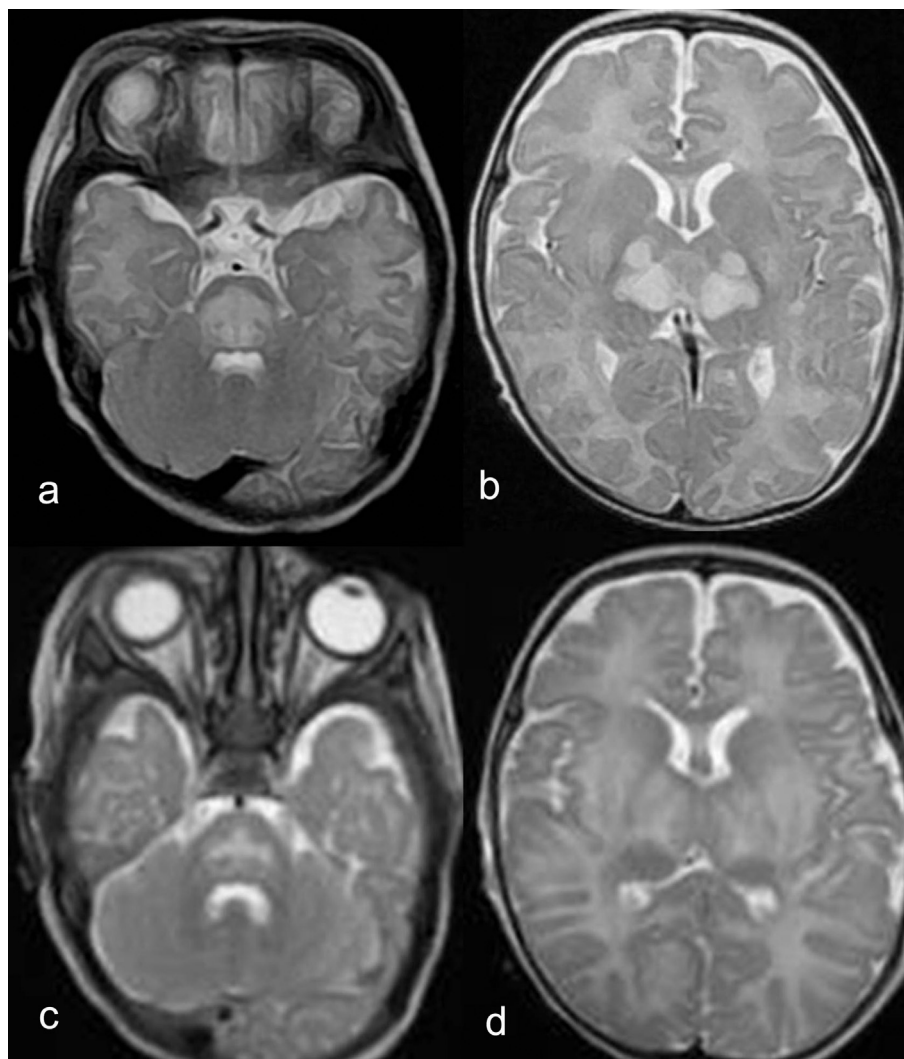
Axial T2-weighted MR images before (a, b) and 4 weeks after (c, d) treatment with thiamin and biotin. Abnormal areas of increased signal intensity in the pons (a). Swelling and abnormal hyperintense areas in the bilaterally globus pallidus, putamina and thalami (b). Follow-up MR image after treatment (c, d) reveals regression of the increased signal in the pons (c), bilaterally globus pallidus, putamina, basal ganglia and thalami (d).
